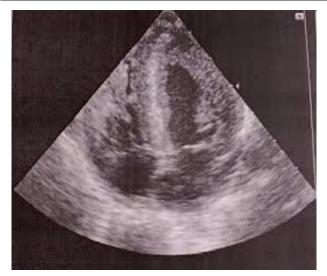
A 2D echocardiogram with an apical 4-chamber view at diagnosis.
